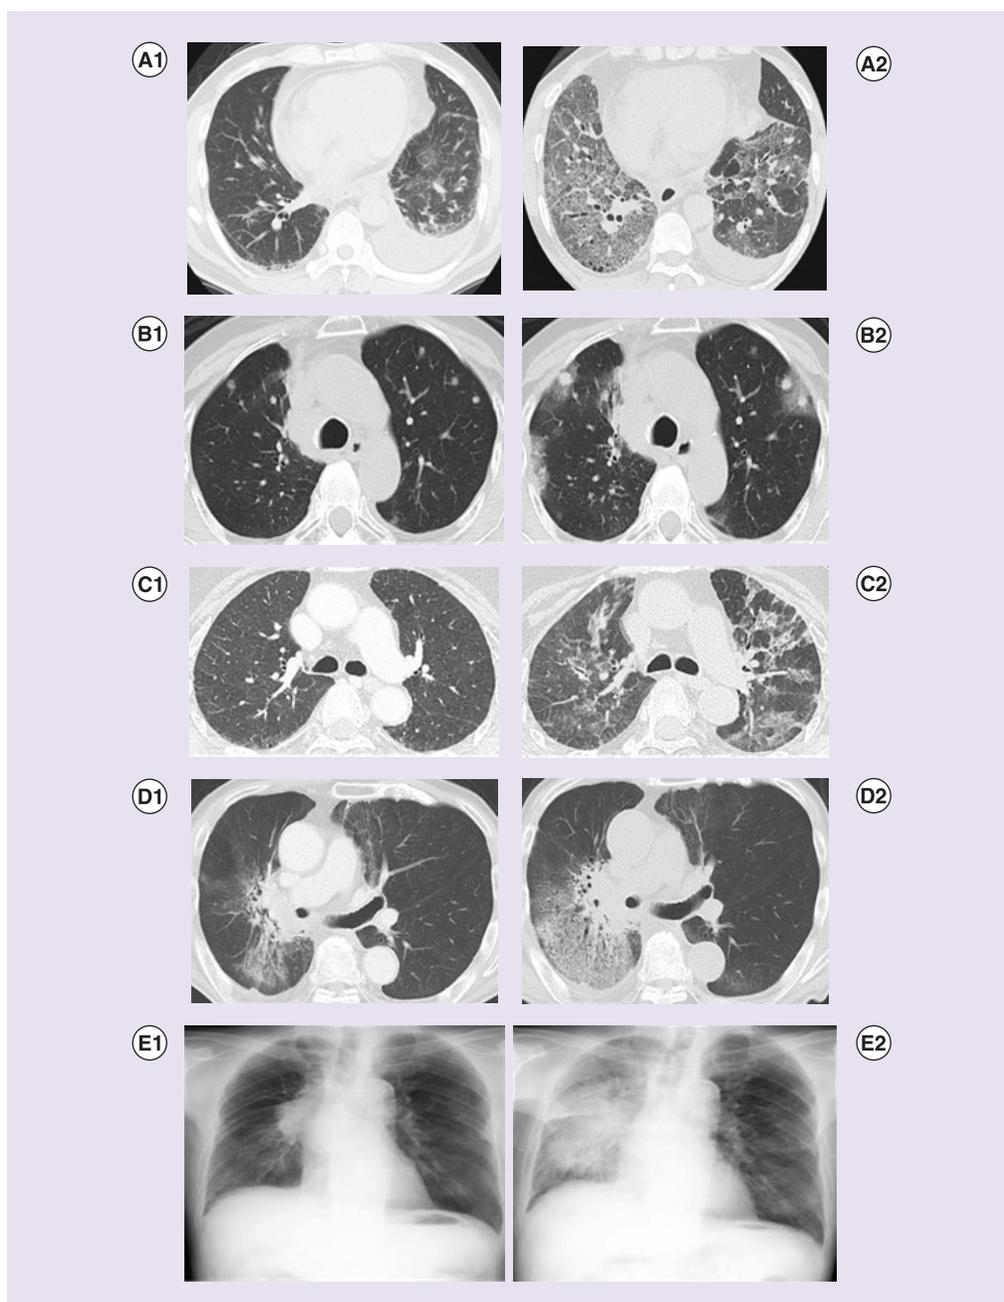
Representative radiological manifestations of nivolumab-associated pneumonitis. (A1), (B1), (C1), (D1), (E1), (F1) are CT images before nivolumab treatment. (A2), (B2), (C2), (D2), (E2), (F2) are CT images at the onset of pneumonitis. (A1) and (A2), pneumonitis with AIP/DAD like pattern in a 57-year-old male with squamous lung cell carcinoma. Ground glass opacities (GGO) appeared in almost all the lung field. Distorted interlobular septa, pleura and vessels indicated diffuse alveolar damage. (B1) and (B2), peritumoral infiltration (PTI) in a 70-year-old female with lung adenocarcinoma. GGO surrounding tumors, so-called PTI, appeared after nivolumab treatment. (C1) and (C2), pattern similar to intensified infection, in a 72-year-old female with melanoma. Onset of interstitial lung disease occurred during the night of the day of the first dose of nivolumab. GGO with a mosaic appearance before treatment, and high beta-D-glucan level (157 pg/ml) at the onset of pneumonitis, suggested pneumocystis pneumonia. This case resulted in a fatal outcome. (D1) and (D2), pattern similar to exacerbation of radiation fibrosis. CT scan before nivolumab treatment was 50 months after the completion of right hilar radiotherapy. Nivolumab reactivated previous radiation fibrosis. (E1) and (E2), infiltration in the ipsilateral lung field in a 74-year-old male with squamous cell lung carcinoma. Consolidation appeared in the ipsilateral lung field with right lung carcinoma.
